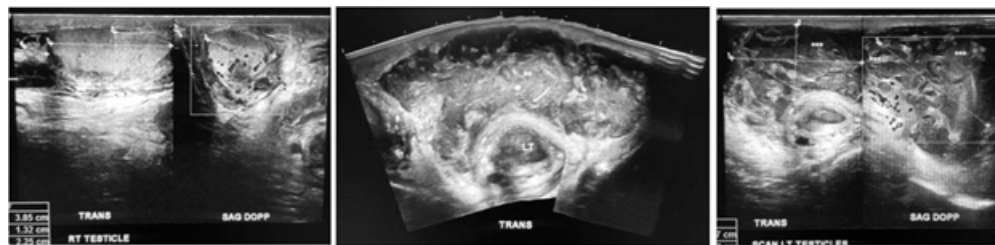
Ultrasonography of right testicle (left), scrotal sac (middle), and left testicle (right).
